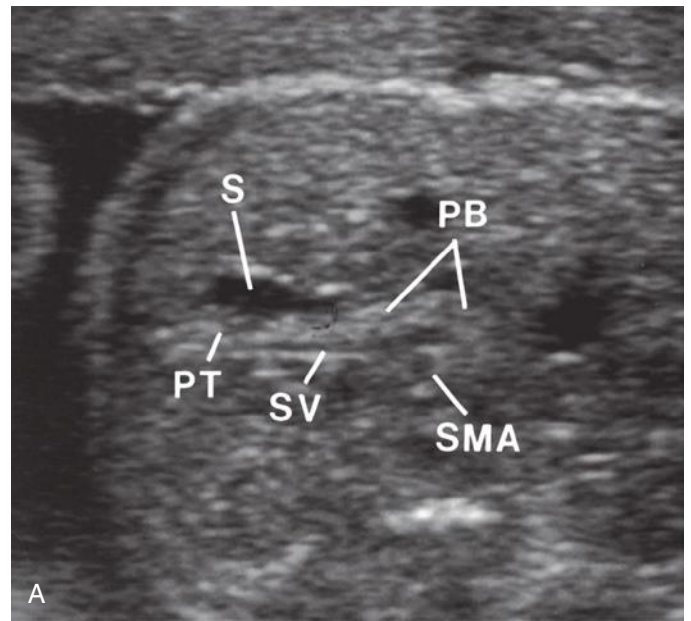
A and B, The fetal pancreas is not commonly seen discretely but is well depicted in these sonograms. When sought, it can often be detected. Those who perform abdominal sonograms in adults and children will recognize the familiar landmarks. In B the pancreas (P) is enlarged (Beckwith-Wiedemann syndrome). The pancreas lies between the splenic vein (SV) and the posterior stomach wall (St). PB, pancreatic body; PT, pancreatic tail; S, stomach; SMA, superior mesenteric artery; SMV, superior mesenteric vein.
